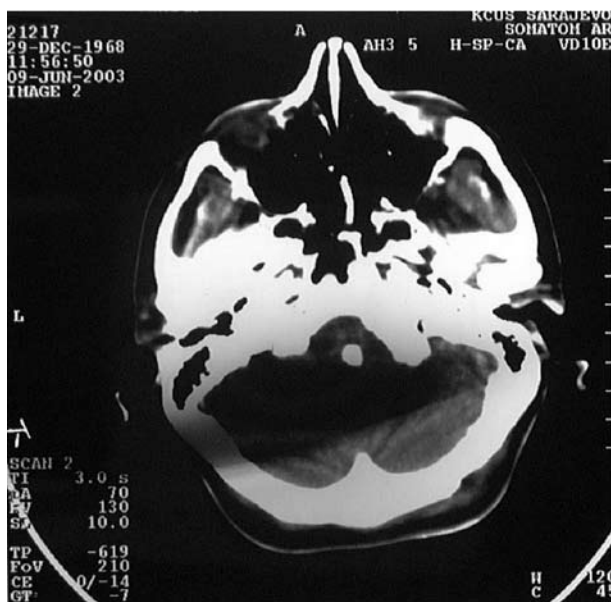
Computed tomography scan of the cervical spine.
